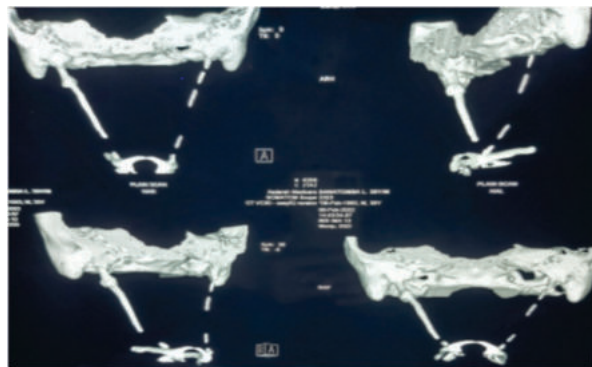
3D CT scan neck showing an elongated right styloid process and a calcified left stylohyoid ligament.
